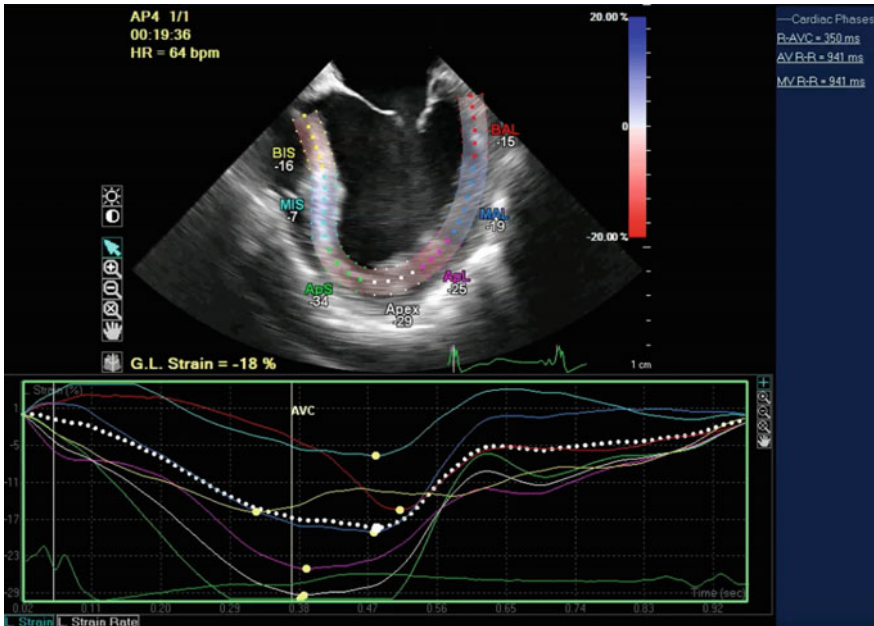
Measurement of global longitudinal strain using speckle tracking in 2D echocardiography. The *individual lines* represent individual segments, while the *white dotted line* represents the global summation of individual strain measurements
